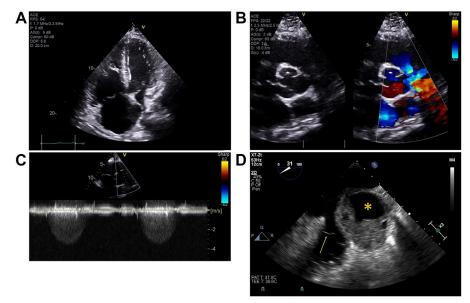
57-year-old with a history of coronary artery disease and prior coronary artery bypass grafting presents with cardiogenic shock. (*A*) Apical four chamber shows a dilated and dysfunctional right ventricle. The interatrial septum is also fixed in the left atrium suggesting elevated right atrial pressures. (*B*) Short axis view at the level of the aortic valve shows turbulent flow on color Doppler in the right ventricular outflow tract. (*C*) Continuous wave Doppler across the right ventricular outflow tract demonstrates a late peaking systolic velocity with a peak gradient of 51 mm Hg consistent with significant stenosis. (*D*) On transesophageal echocardiogram, there is a partially thrombosed saphenous vein graft aneurysm (*) extrinsically compressing the proximal pulmonary artery immediately distal to the pulmonic valve (*arrow*).
